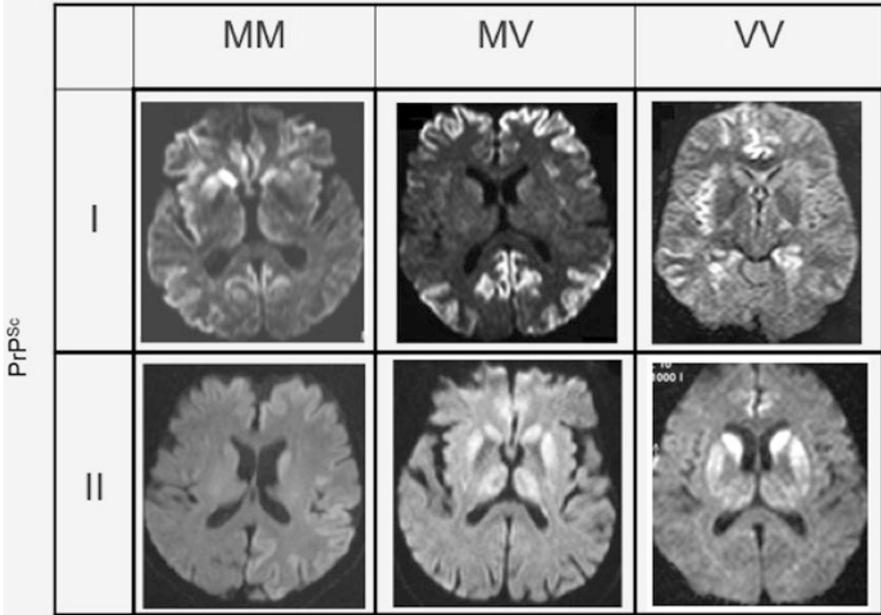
Characteristic MRI findings in sporadic CJD subtypes
